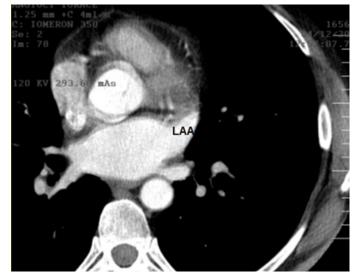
Computed tomography of the heart. In the same view the LAA and LSPV are visible, together with the RSPV. Veins that are found in the same plane with LAA are superior veins. LAA presents trabeculations inside it.
